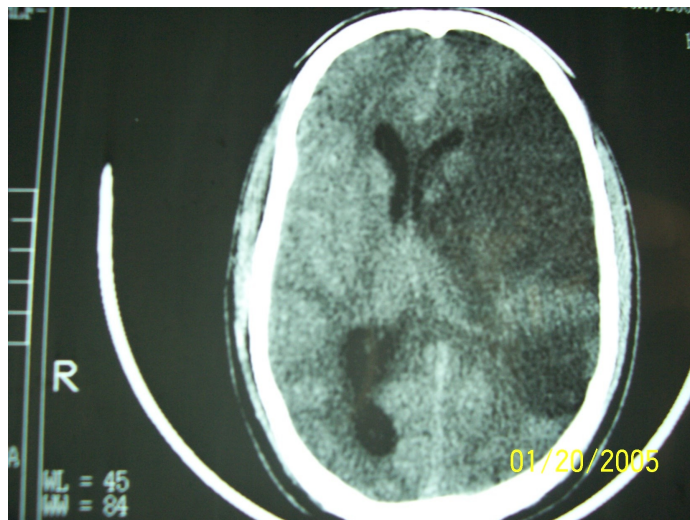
a CT SCAN OF A PATIENT WITH GLOBAL APHASIA
